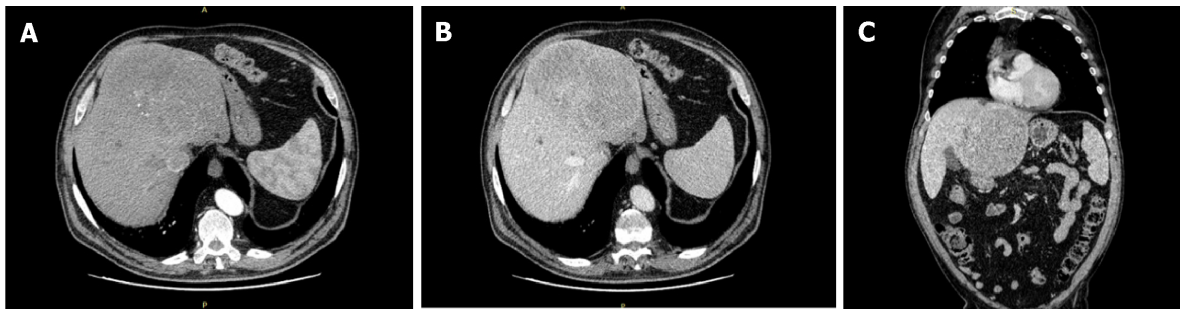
Abdominal computed tomography displaying the left liver mass. A: Arterial phase. B: Portal phase. C: Coronal view.
